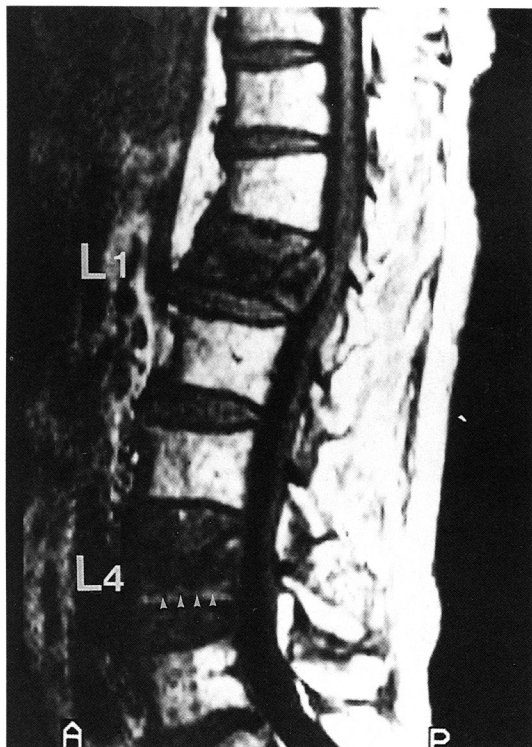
Types Ia and Ic compression fractures in a 51-year-old man with a history of trauma 1 month prior. T1-weighted MR image shows diffuse hypointensity (type Ia) in L1 and band-like hypointensity (type Ic) compression fracture in L4 (arrow heads).
